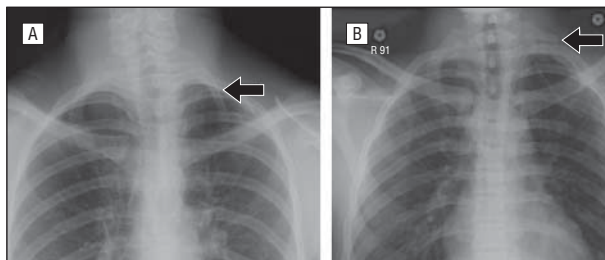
Preoperative chest radiographs of 2 patients with arterial thoracic outlet syndrome. A, A patient with a cervical rib fused to the first rib (arrow). B, A rudimentary rib (arrow).
